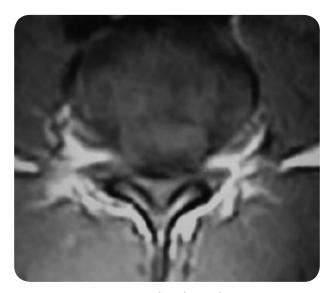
A T2 axial cut weighted MR image showing Left L4/5 disc prolapse impinging L5 root and narrowing the lateral recess. Of note also the bright signal intensity of the non-degenerated disc.
